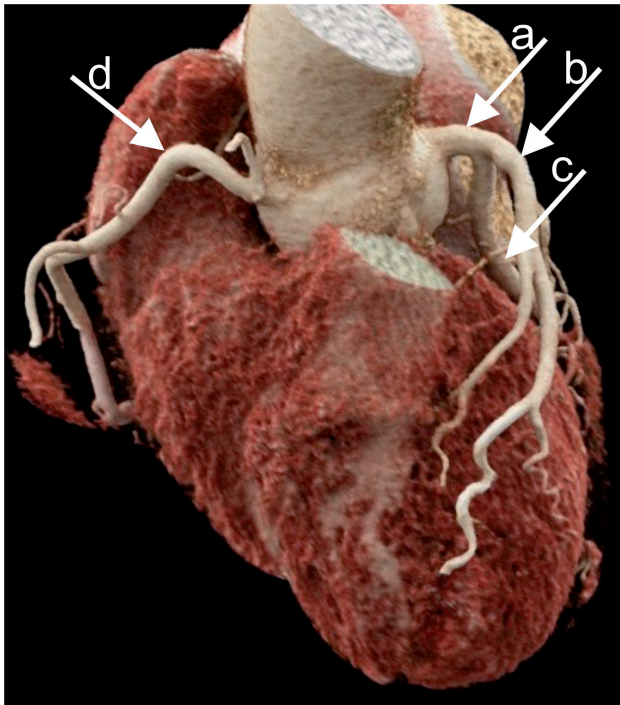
Computed tomography (CT) images of a 65-year-old woman depicting a 3D reconstruction (using volume rendering technique) of a normal coronary tree (a: LM – left main stem; b: LAD – left anterior descending artery; c: CX – left circumflex artery; d: RCA – right coronary artery), along with multiple 3D reconstructions. The dual source 3rd generation CT Somatom Force device (Siemens Healthcare GmbH) was used to acquire the image.
